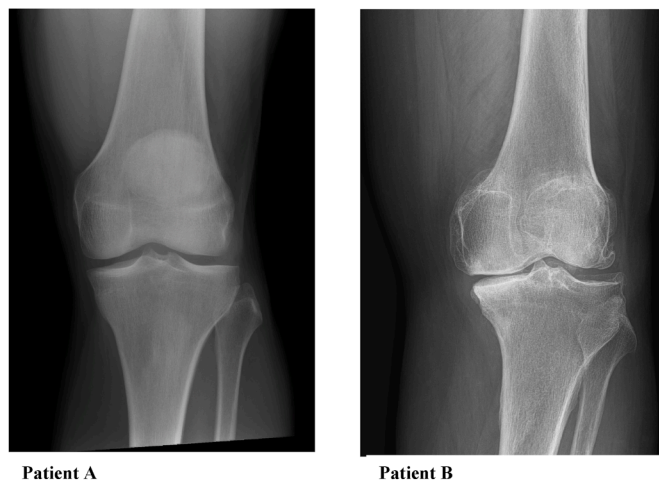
Knee x-ray comparative images (patient A²⁶ and patient B²⁷).
